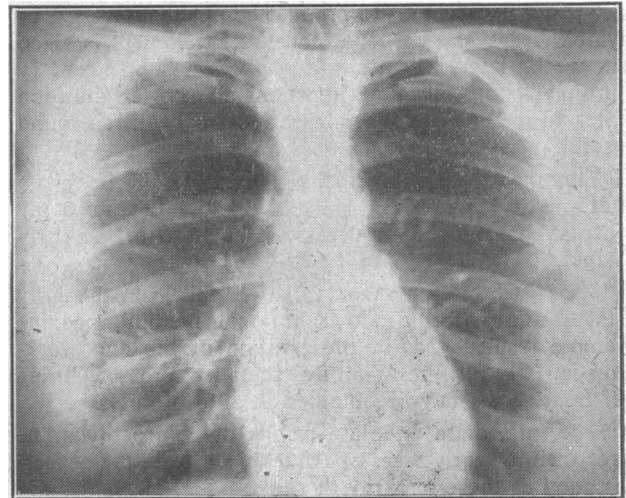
Case 2: X-ray appearances after first course of treatment (March, 1949).
